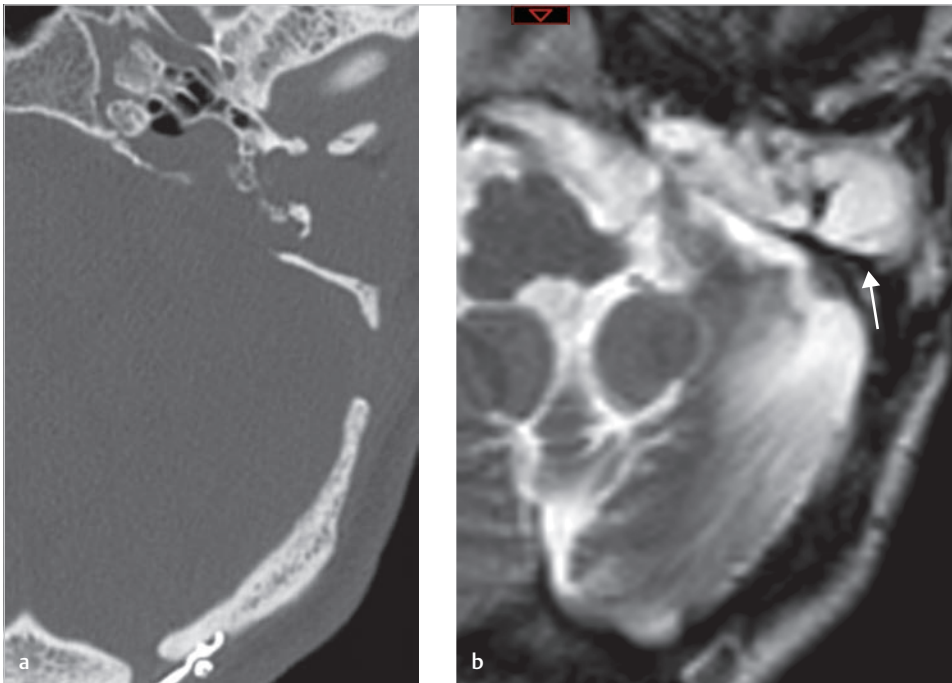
The patient suffered from meningitis with facial weakness with dead ear 2 years before and underwent two surgeries elsewhere through transmastoid and retrosigmoid approaches. The axial CT (a) shows incomplete access to the petrous apex from both lateral and posterior, and the T2-weighted MRI (b) demonstrated large ischemic change in left cerebellar hemisphere due to compression during retrosigmoid approach. Recurrent cholesteatoma filling the temporal bone is demonstrated in high signal (arrow).
